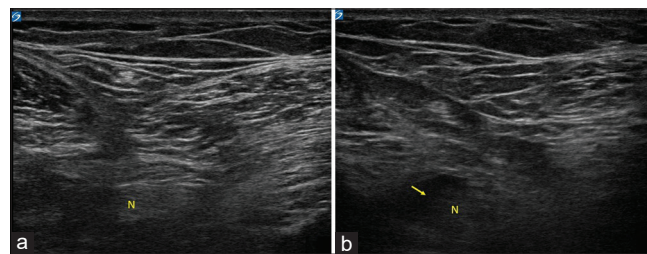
Ultrasound image showing the sciatic nerve at the proximal level (mid-thigh). (a) Before saline pre-injection; (b) after saline pre-injection. N, sciatic nerve; arrow, pre-injected saline
